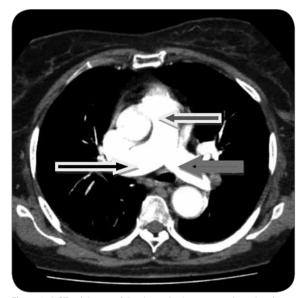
A CT axial scan of the thorax in the same patient showing opacification of the main pulmonary trunk (top left arrow, white outline) and pulmonary arteries (right black arrow showing the right pulmonary artery and the bottom left arrow, thick grey outline, showing the left pulmonary artery) after breathing normally during the scan.
